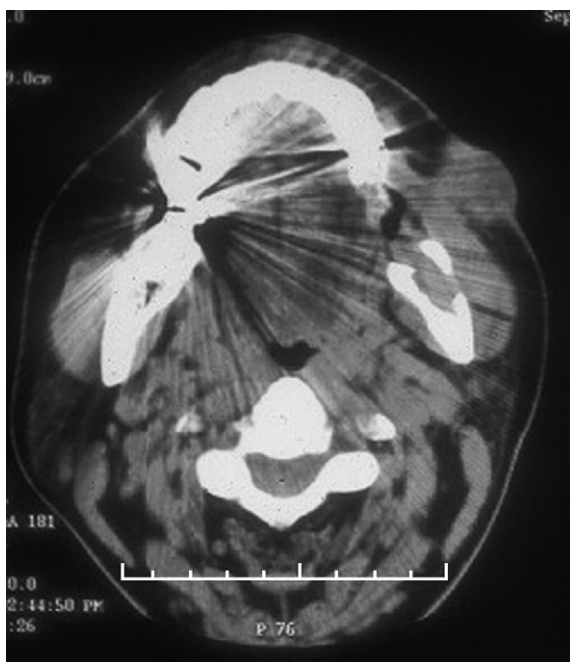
CT scan results, showing a left buccal mass that has spread from the skin to the masseter muscle.
